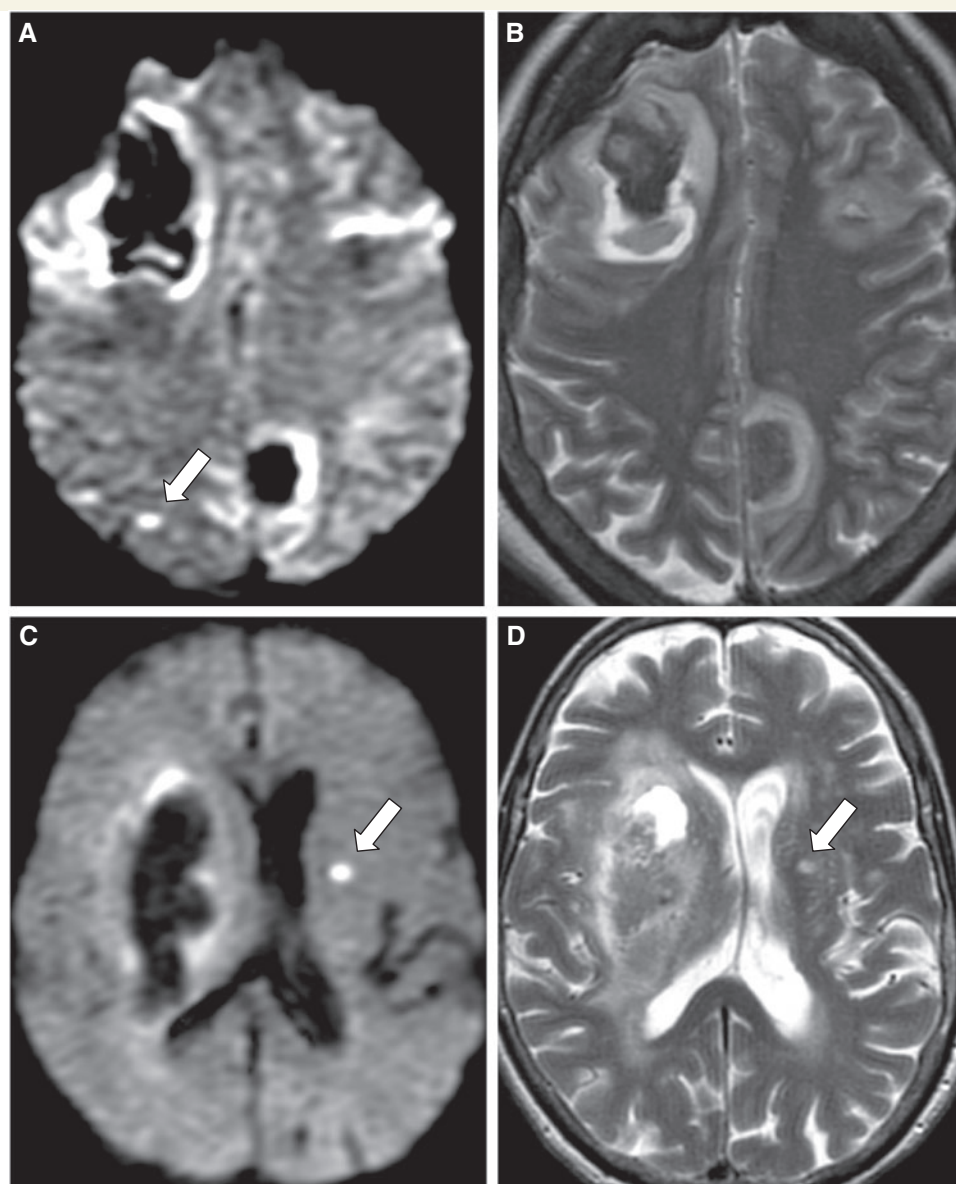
Examples of positive DWI lesions. (A and B) Probable CAA-related intracerebral haemorrhage. (A) DWI sequence showing presence of small ischaemic lesion in the right parietal lobe (white arrow) in the presence of two lobar intracerebral haemorrhage, frontal and parietal, suggestive of CAA; (B) corresponding T_2 -weighted sequence. (C and D) Non-CAA-related intracerebral haemorrhage. (C) DWI sequence showing presence of small lacunar ischaemic lesion in the left lentiform nucleus (white arrow) in the presence of deep intracerebral haemorrhage; (D) a small infarct is visible on the corresponding T_2 -weighted sequence (white arrow).
